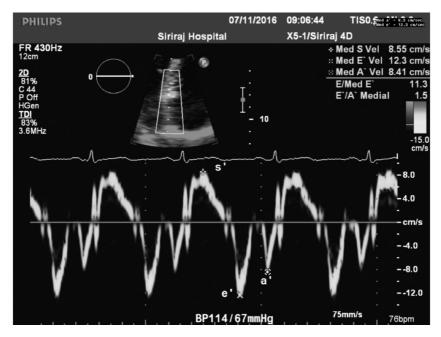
Measurement of tissue Doppler imaging Tei index. A', tissue Doppler imaging during late diastole; E', tissue Doppler imaging during early diastole; S', tissue Doppler imaging during systole. All data analysis was performed using SPSS Statistics version 15 (SPSS, Chicago, IL). Continuous variables are expressed as mean \pm standard deviation or median and range. Categorical variables are presented as frequency and percentage. Baseline data of patients in the three study groups were analyzed by one-way ANOVA, followed by Bonferroni correction for multiple comparisons of continuous variables. Chi-square test was used to analyze categorical variables. One-sample *t*-test was used to analyze data compared to normal values. A *p*-value<0.05 was regarded as being statistically significant.
